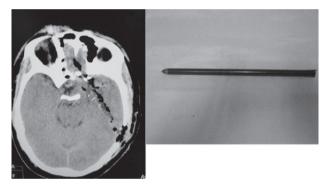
Post-operative CT scan showing the arrow tract
